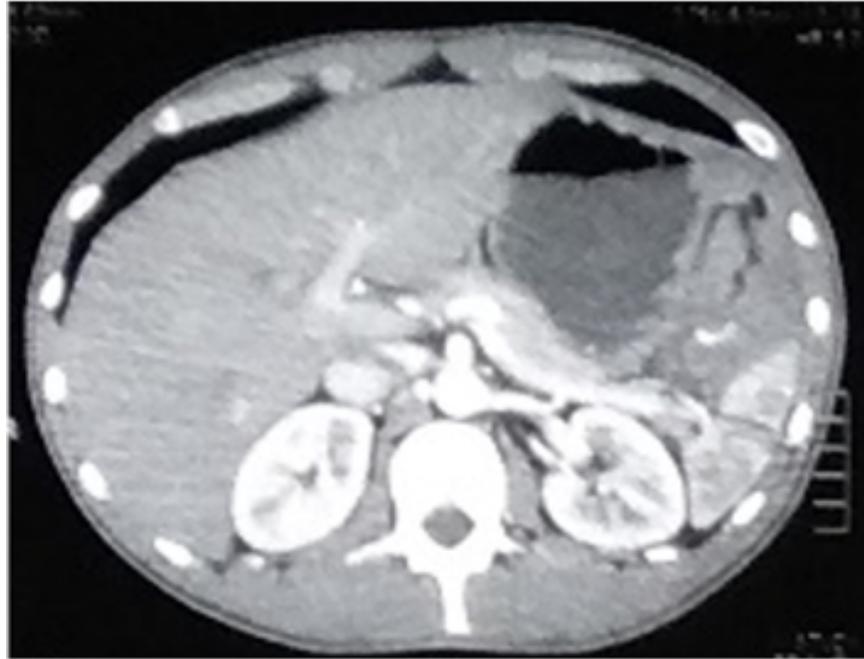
Contrast Enhanced CT scan showing hematoma in perisplenic region
